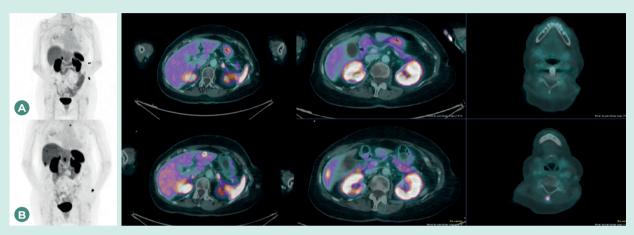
Response to treatment: (A) Control Ga⁶⁸ DOTATOC PET/CT, disappearance of the pathological deposits of the radiopharmaceutical is observed. (B) PET/CT Ga⁶⁸ DOTATOC pretreatment
